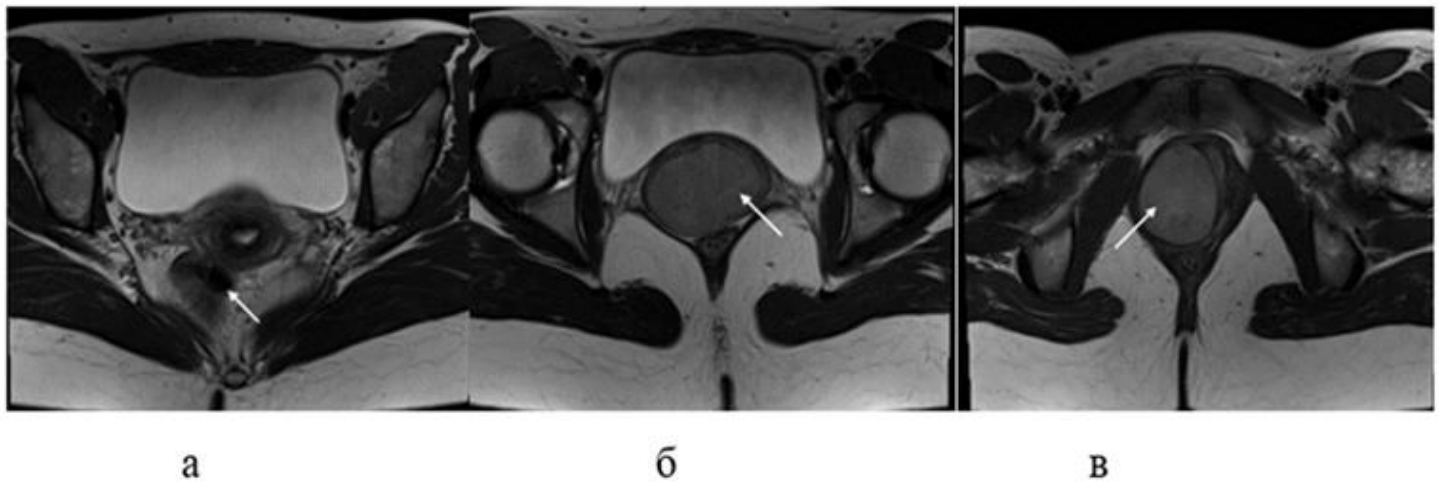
MRI images of axial sections of the small pelvis: a – level of the cervix; b – level of the first formation; c – level of the second formation.
